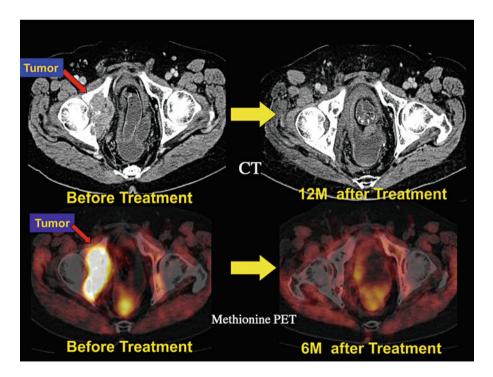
This patient is a 65-year-old male with locally recurrent rectal cancer. A CT scan and PET scan revealed a tumor mass in the right sidewall of the pelvis and infiltrated pelvic bone
